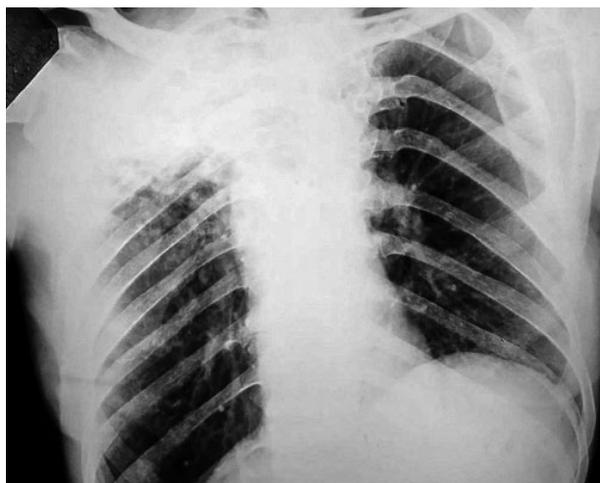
A 51-year-old woman; chest X-ray at the end of the intensive treatment phase shows infiltration in the right lung, indicating absence of radiological improvement
